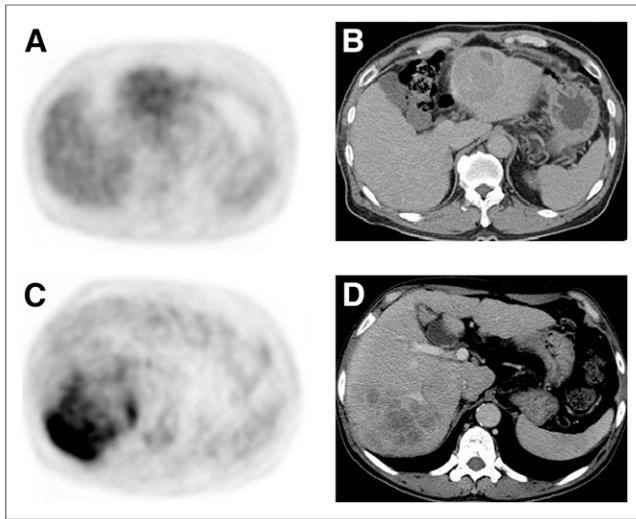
(A and B) HCC in left hepatic lobe shows low ^{18}F -FDG uptake (TLR, 1.5). This patient survived for 20 mo. (C and D) Heterogeneous high ^{18}F -FDG uptake (TLR, 4.3) is seen in right hepatic lobe, and this patient died after 2 mo. Both patients had bone metastasis.
